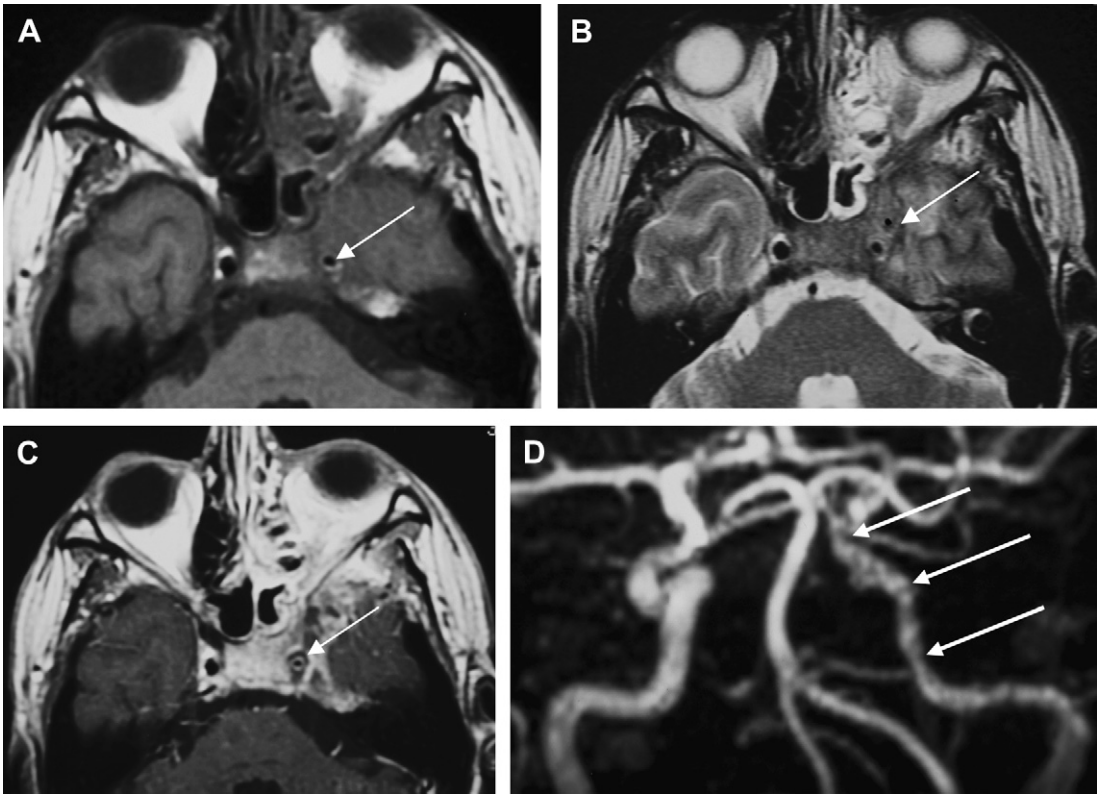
Axial T1-weighted (A), T2-weighted (B), and postgadolinium T1-weighted (C) images show extensive replacement of the central bony skull base by a soft tissue mass that extends from the nasal cavity and paranasal sinuses into the pterygopalatine fossa and inferior orbital fissure and, posteriorly, into the left cavernous sinus encasing the left internal carotid artery (*white arrows in A–C*). This soft tissue mass is of low signal intensity on the T2-weighted images and enhances intensely after administration of gadolinium. Magnetic resonance angiography, (D) demonstrates to advantage the stenosis and irregularity of the lumen of the left internal carotid artery along the petrous and cavernous segments (*white arrows*).
